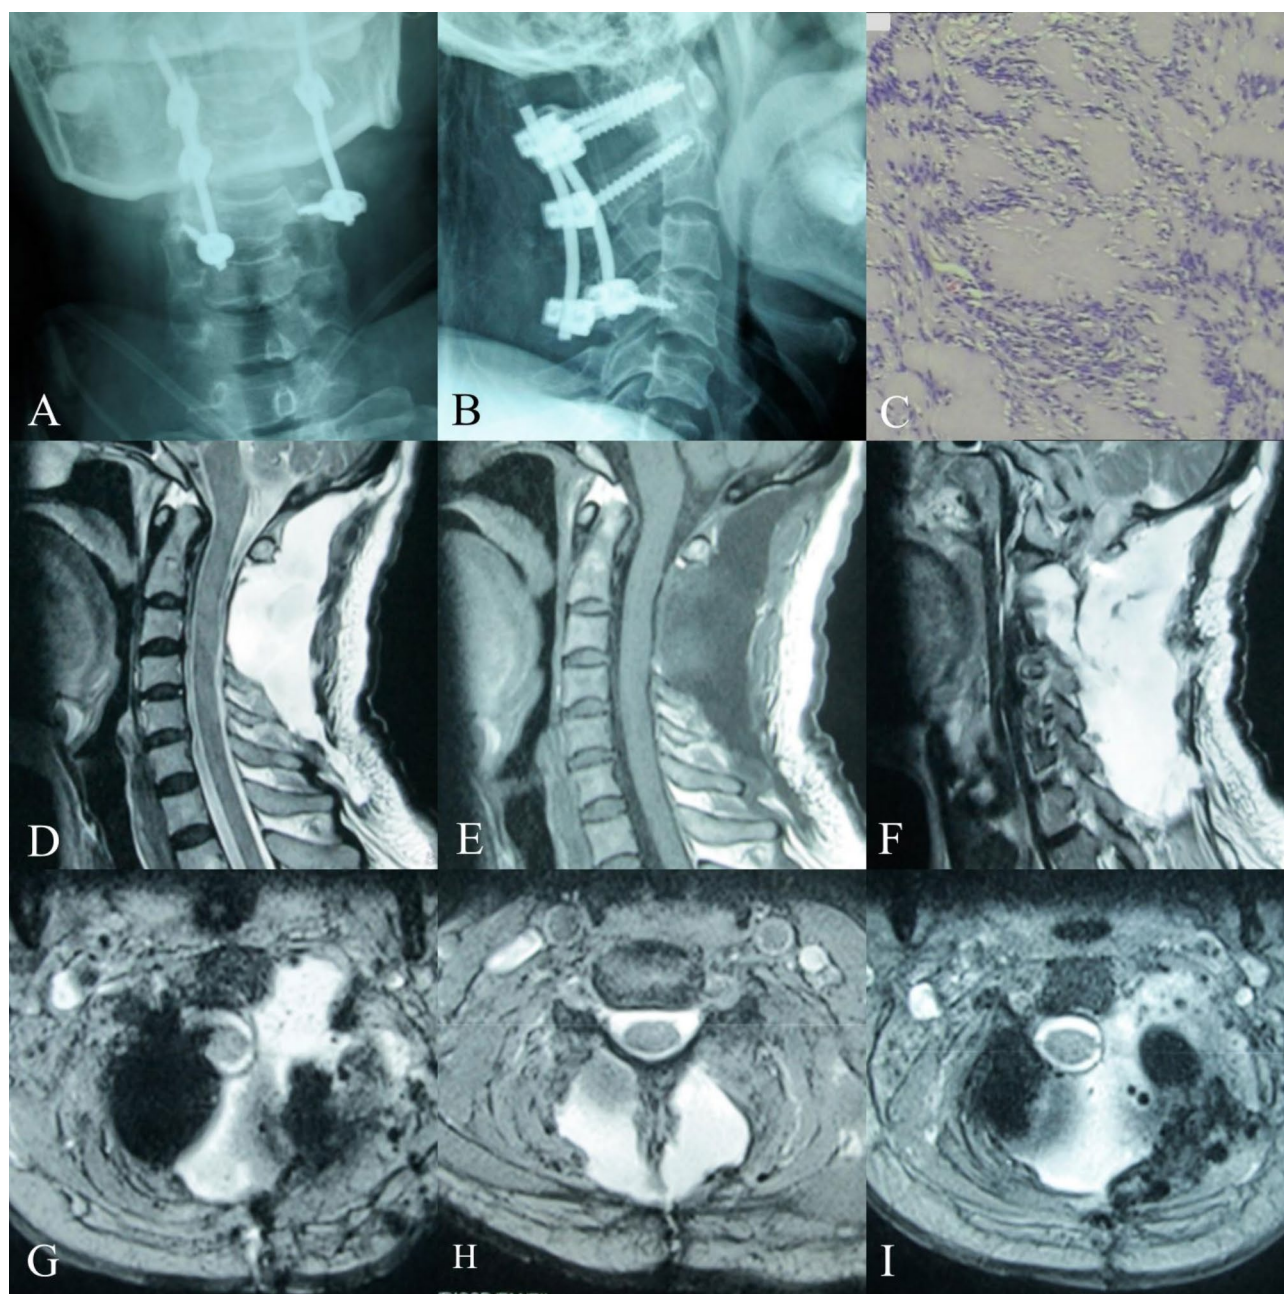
Postoperative imaging and pathological data: A–B: postoperative X-ray film shows posterior cervical internal fixation in place; C: Neurilemmoma indicated by pathology; D–I: After cervical spine surgery, MRI showed that the tumor had been completely removed, but a large area of cerebrospinal fluid leakage remained
